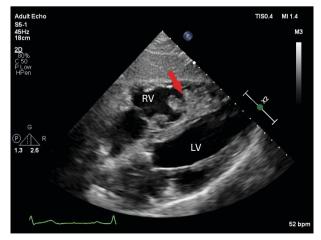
Subcostal view on transthoracic echocardiogram showed an irregular shaped echogenic mass (red arrow) in the RV attached to the right ventricular apex and septal wall. LV: left ventricle, RV: right ventricle.
